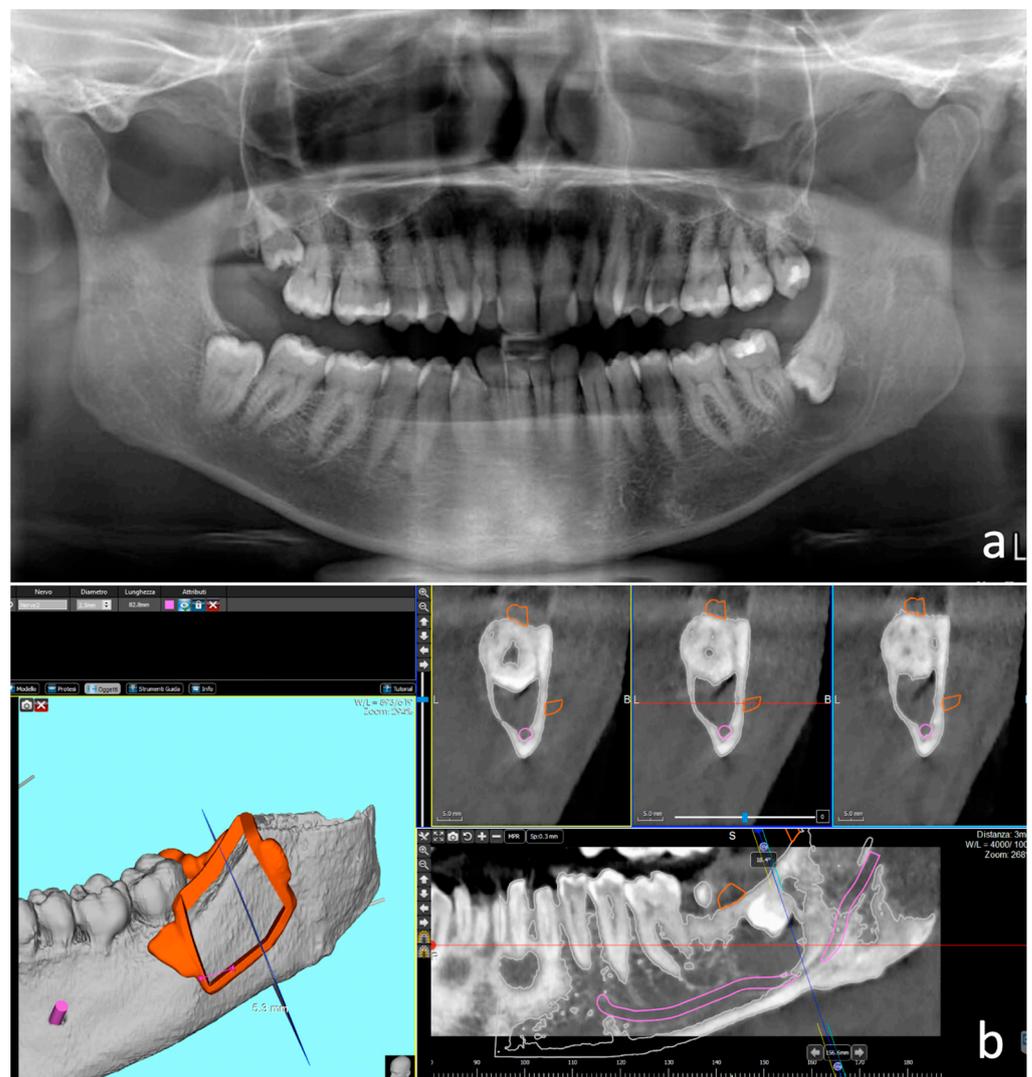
Case 1. Odontogenic follicular cyst associated with fully included tooth 38. (a) Orthopantomography; (b) CT scan with the design of the cutting guide for the bone lid execution. The guide was designed with mixed bony and dental support, and stabilisation by a mesial fixation screw.
